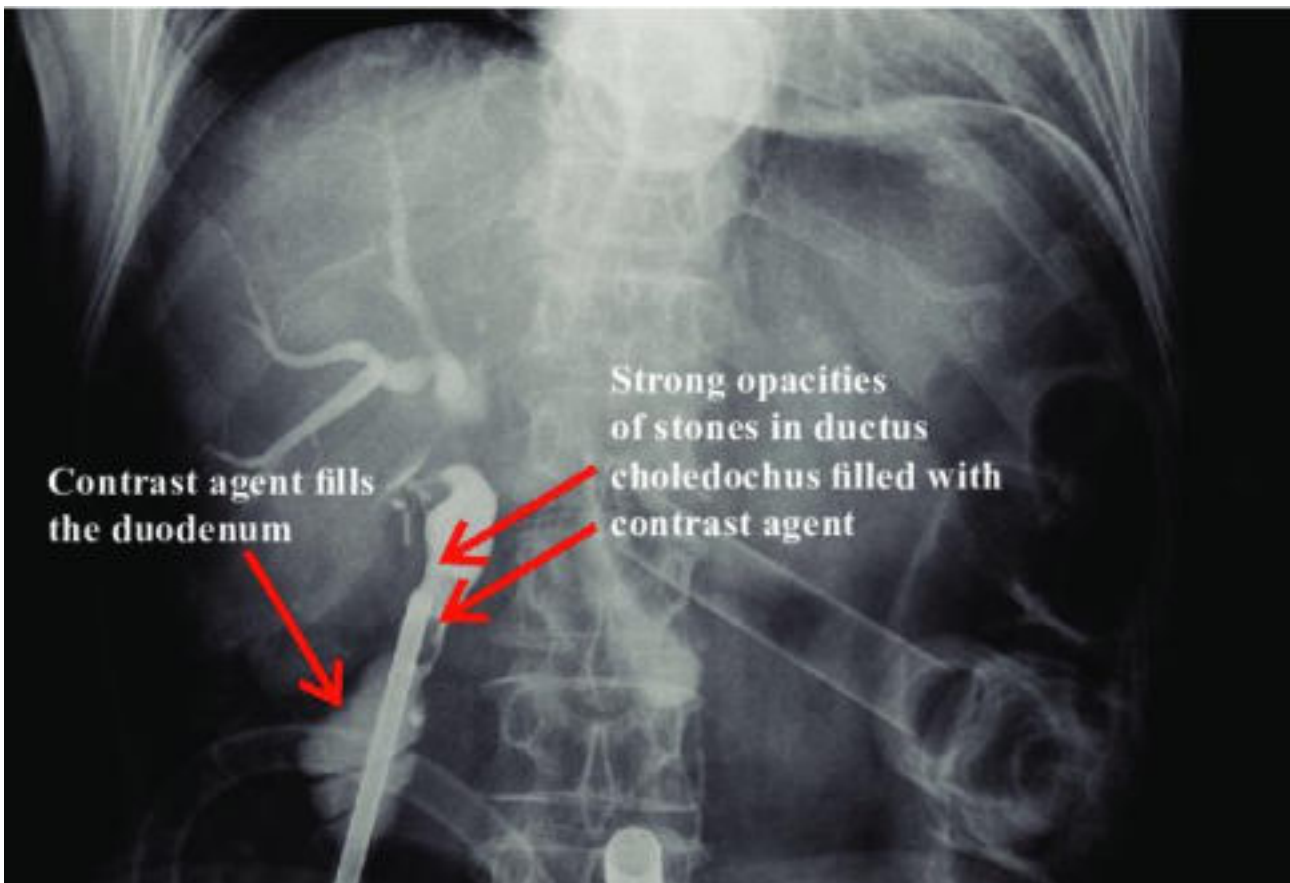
Intraoperative cholangiography (intraoperative ultrasound
